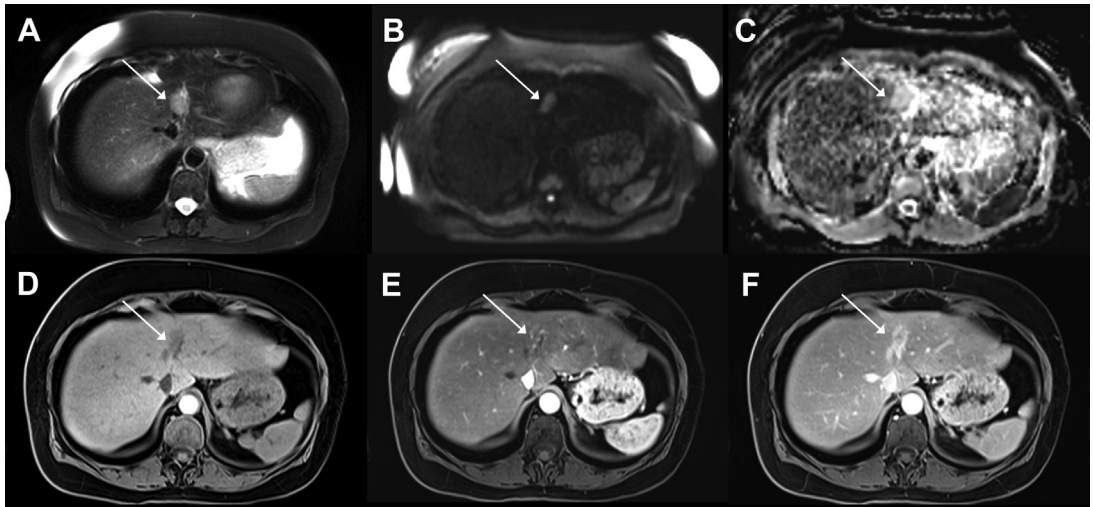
Pitfalls of sclerosed hemangioma. Lesion with faint hyperintensity on fat-saturated T2-weighted image (A), hyperintensity on diffusion (B) without restriction (C), hypointensity on fat-saturated T1-weighted image (D) with faint peripheral hyperenhancement in the arterial phase (E) and heterogeneous rim hyperenhancement in the delayed phase (F). Despite the reassuring lack of diffusion restriction, a biopsy was performed to exclude fibrotic malignant lesions, and the diagnosis of sclerosed hemangioma was confirmed.
